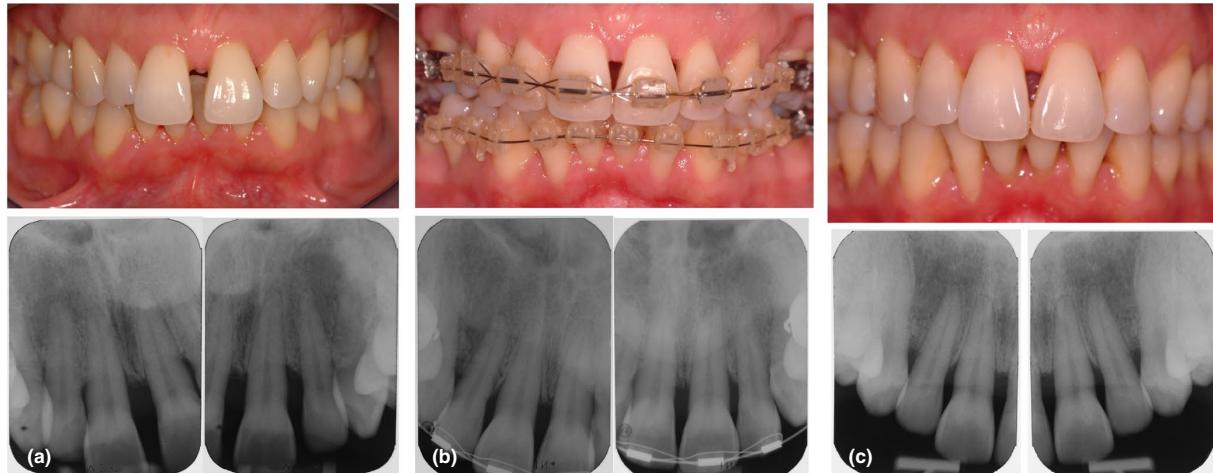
(a) Clinical and radiographical situation after initial therapy. (b) Clinical and radiographical situation 1 year after regenerative therapy. (c) Clinical and radiographical situation 4 years after regenerative therapy
